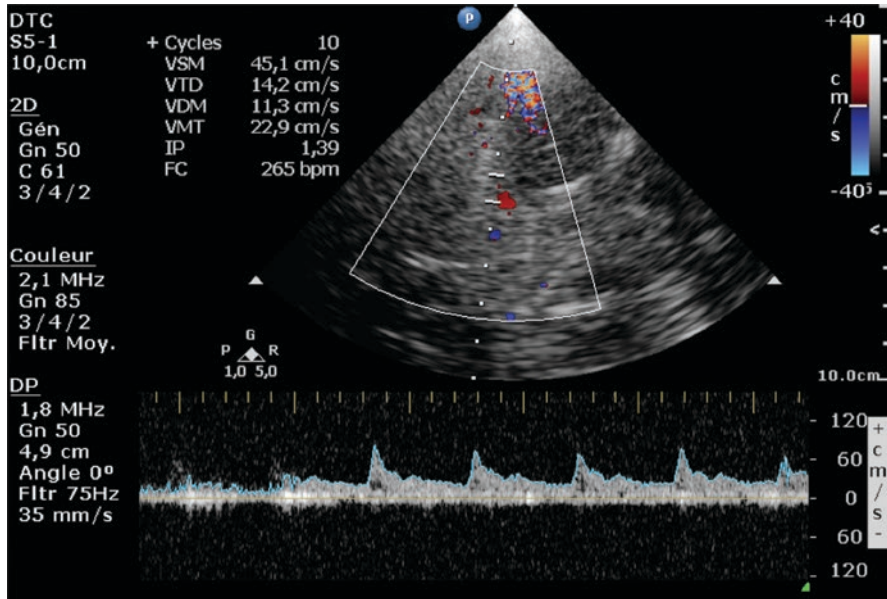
Transcranial Doppler (TCD/TCCS) recording from the middle cerebral artery after severe TBI. Decrease in end-diastolic velocity (EDV) and increase in pulsatility Index (PI) are related to a rise in distal cerebrovascular resistance, which may be due to increased intracranial pressure (ICP)
